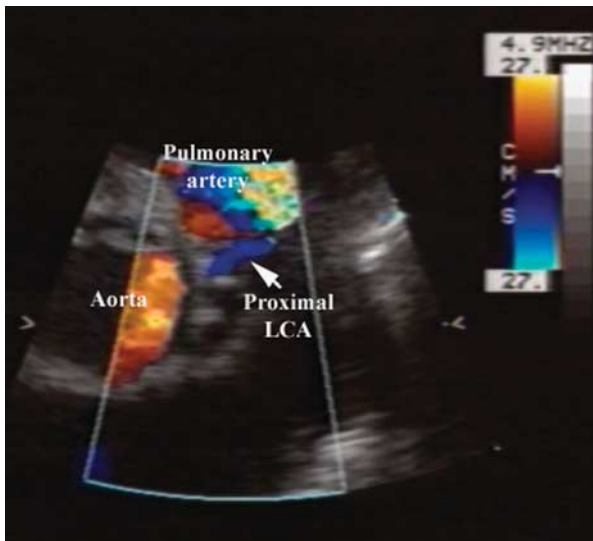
Low velocity colour flow mapping in the parasternal short axis shows retrograde filling of the main stem of the left coronary artery (LCA). A filling defect is evident between the LCA and the aorta, due to the non-patency of the proximal part of the coronary artery (arrow).
